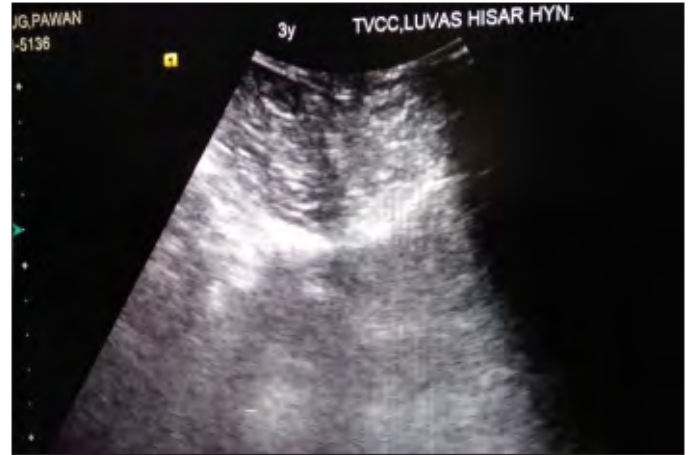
Ultrasonography over the swelling showing soft tissue density
